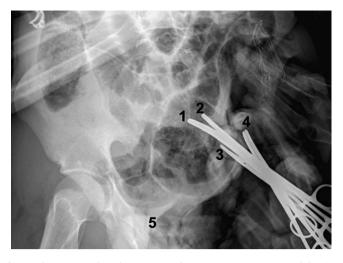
Pelvic X-ray study in the emergency department on patient's arrival showing no bony structure on the left side of the pelvic–1: left iliac vein; 2: left iliac artery; 3: left internal iliac artery; 4: left internal iliac vein; 5: original symphysis location.
